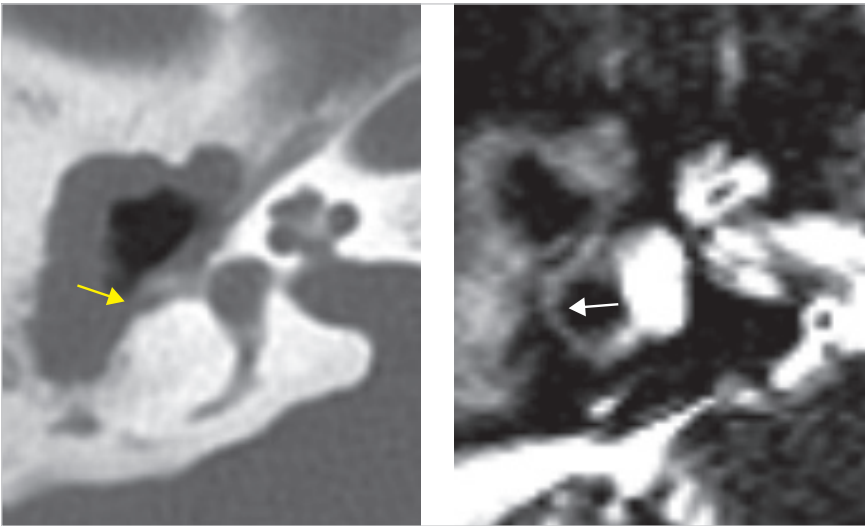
A case of cholesteatoma in a contracted mastoid with large fistula in lateral and superior semicircular canals. As seen in the CT, cholesteatoma erodes the lateral semicircular canal extensively (*yellow arrow*). The T2-weighted image of MRI indicates decreased signal intensity of the canal (*white arrow*), implying some scarring process in the canal. In spite of such change, the bone conduction remains near normal.
